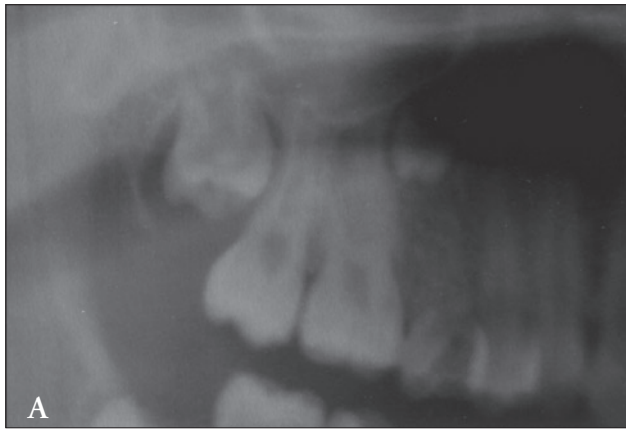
Radiograph of a 14-year-old female depicting an impacted maxillary right second premolar with completed crown formation. Figure 1B. One year follow-up radiograph showing no evidence of root formation or eruption of the impacted maxillary right second premolar. Figure 1C. Three years later, the impacted maxillary right second premolar is showing that root trunk formation has been initiated. However, no significant change in coronal position is evident. Also evident is the completed eruption of maxillary and mandibular third molars.
